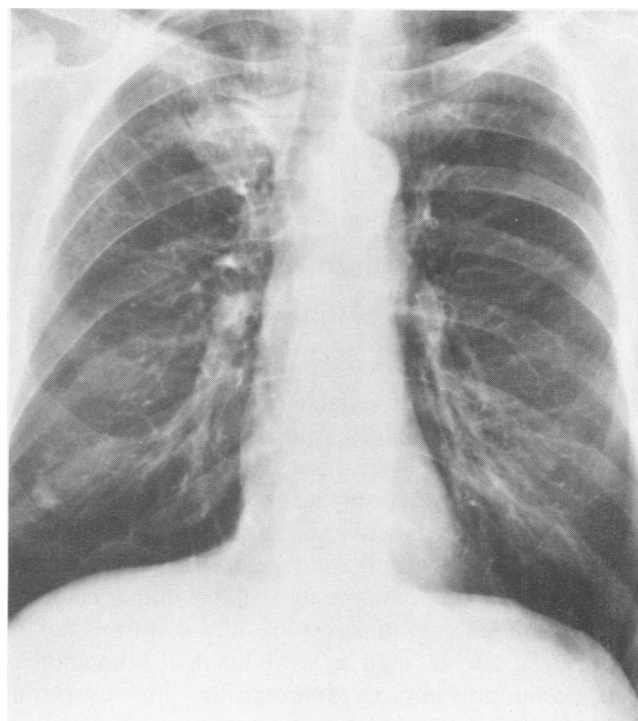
This PA roentgenogram reveals a small T-1 lesion in the right upper lobe and is typical of the many T-1 N-0 bronchioloalveolar carcinomas that were entered on the study.
